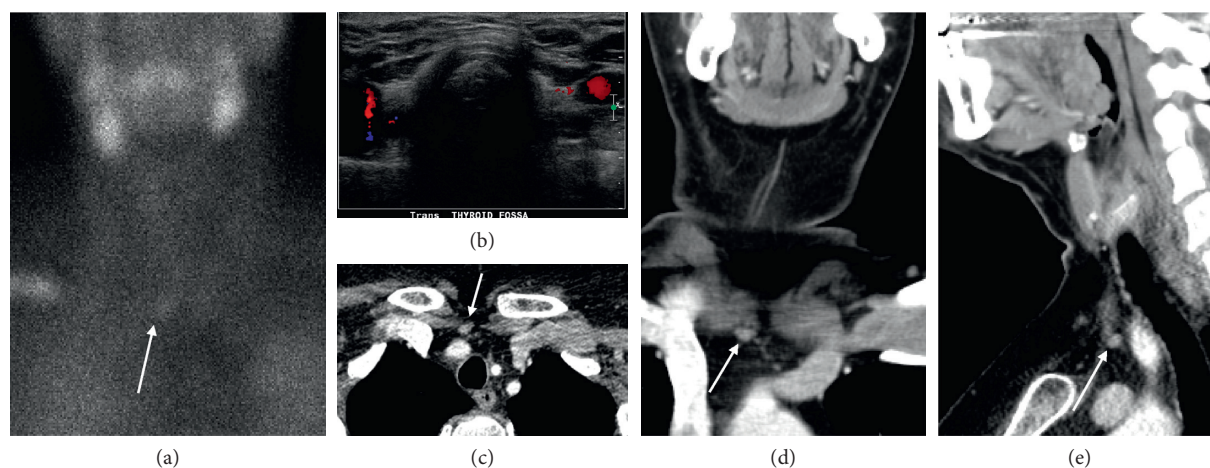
Inconclusive sestamibi scintigraphy versus ultrasound with successful localization by four-dimensional computed tomography (4DCT). A 49-year-old female with multiple endocrine neoplasia type 1 (MEN1) and remote prior three-gland parathyroidectomy presents with recurrent hyperparathyroidism. Planar delayed (two hours) sestamibi scintigraphy (a) shows a questionable-inconclusive enlarged right hypermetabolic parathyroid gland in the superior mediastinum (white arrow). Ultrasound with Doppler interrogation (b) is negative for recurrence. Axial (c), coronal (d), and sagittal (e) arterial phase 4DCT was performed to clarify discordant first-line findings and confirm a small hyperenhancing and ectopic right intrathyroidic parathyroid adenoma (white arrows).
